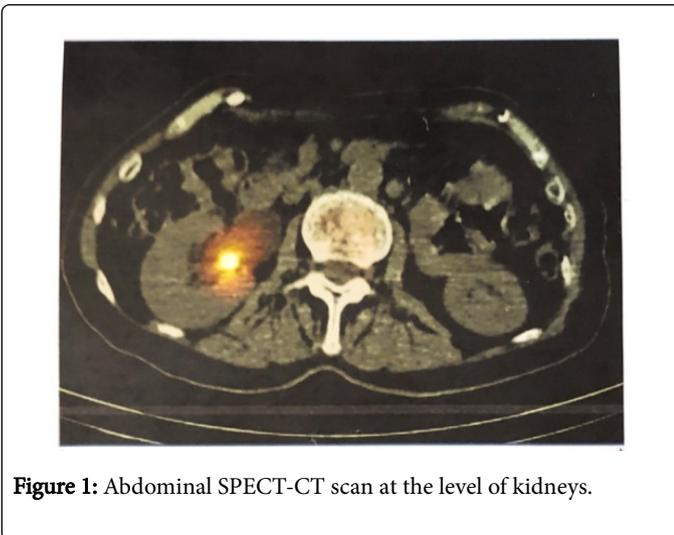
Abdominal SPECT-CT scan at the level of kidneys.
